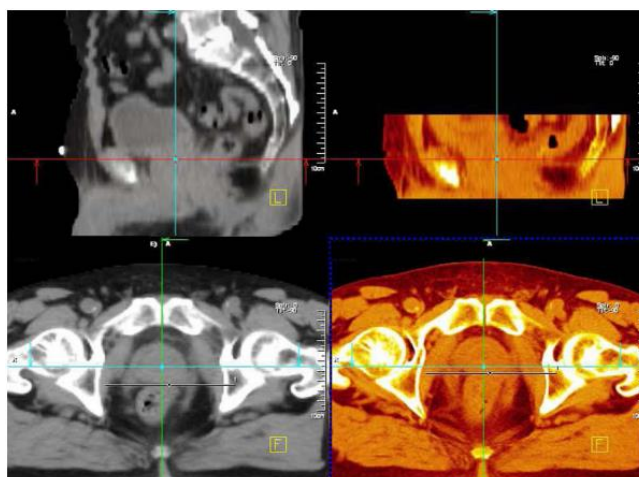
Comparison between slice of pre-treatment (grey image) and planning slice of CT (colourful image) [48]
